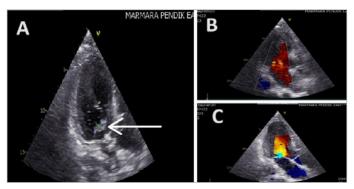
(A) Transoesophageal echocardiography showing a 12x9 mm vegetation on the anterior leaflet of both mitral valve leaftles. (B and C) The presence of mitral valve regurtitation.
